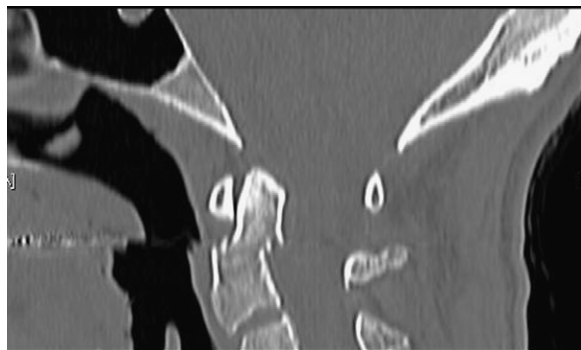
Sagittal reformat CT scan (bone windows) with apparent fracture through the base of the odontoid peg. Closer inspection reveals a step deformity in the soft tissues of the oropharynx suggesting artefact.
